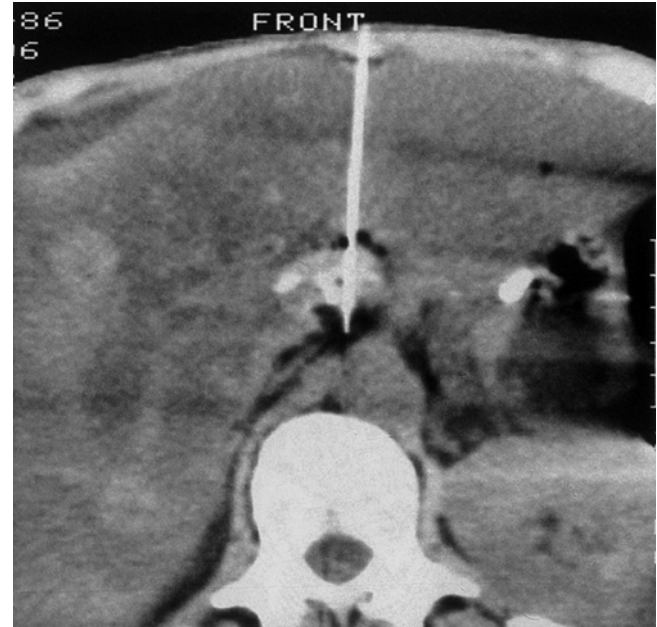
Ventral transhepatic CT-guided injection. Several access routes are possible in celiac plexus injection. In this case, the injection was carried out using a ventral transhepatic approach. The tip of the needle lies directly alongside the celiac trunk. The alcohol spreads precisely within the celiac plexus (Reproduced with permission from Danilo Jankovic)
